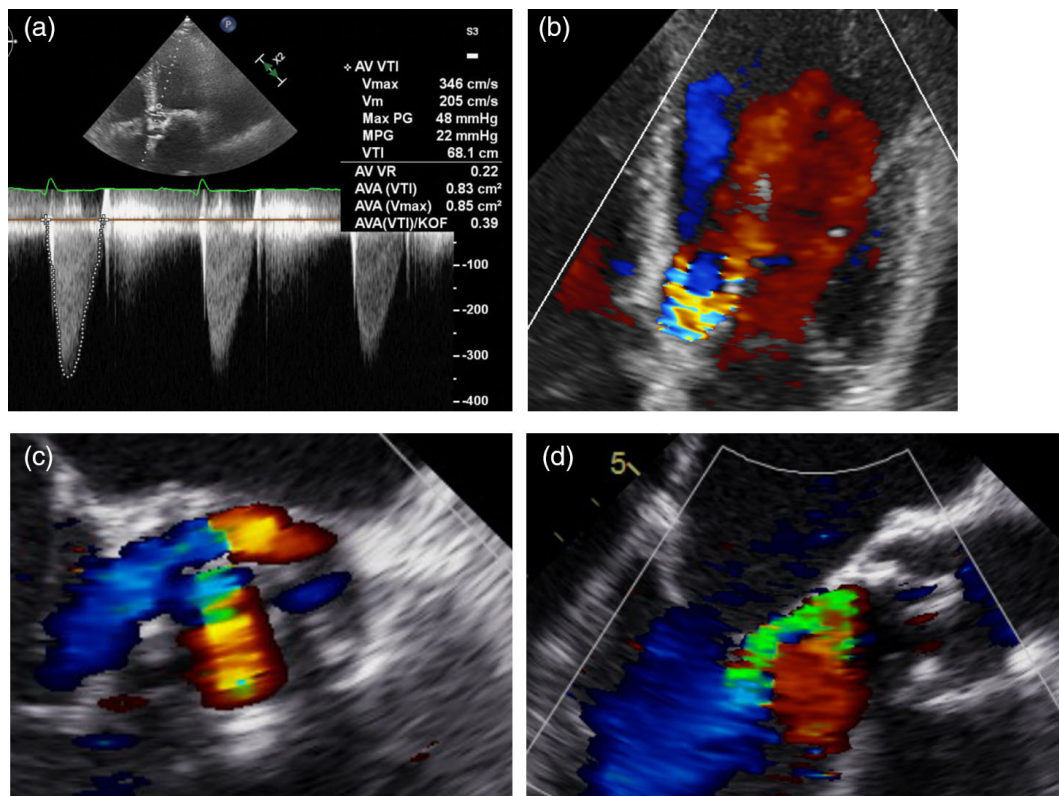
Transthoracic echocardiography revealing both prosthetic aortic valve stenosis and regurgitation (a, b). Intraoperative transesophageal echocardiography showed PVL alongside Mosaic prosthesis (c, d)
